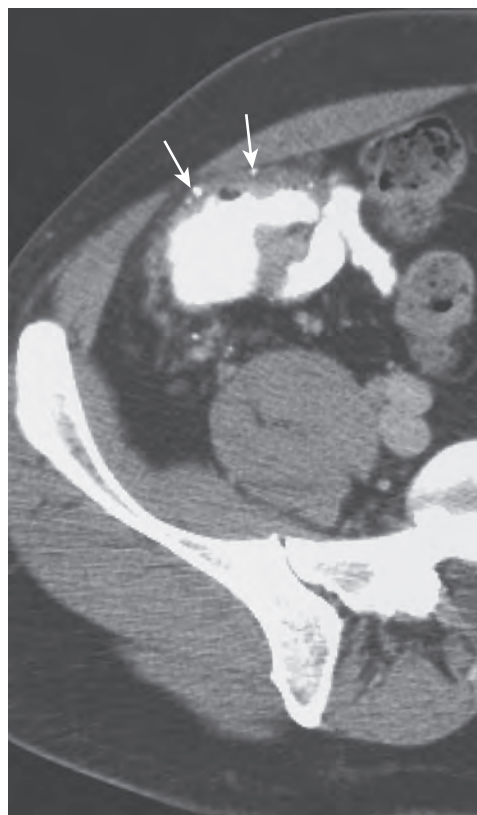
Hemangioma of the colon. CT scan shows lobulated thickening of the circumference of the wall of the cecum with numerous calcified phleboliths (arrows) in the subserosa.
